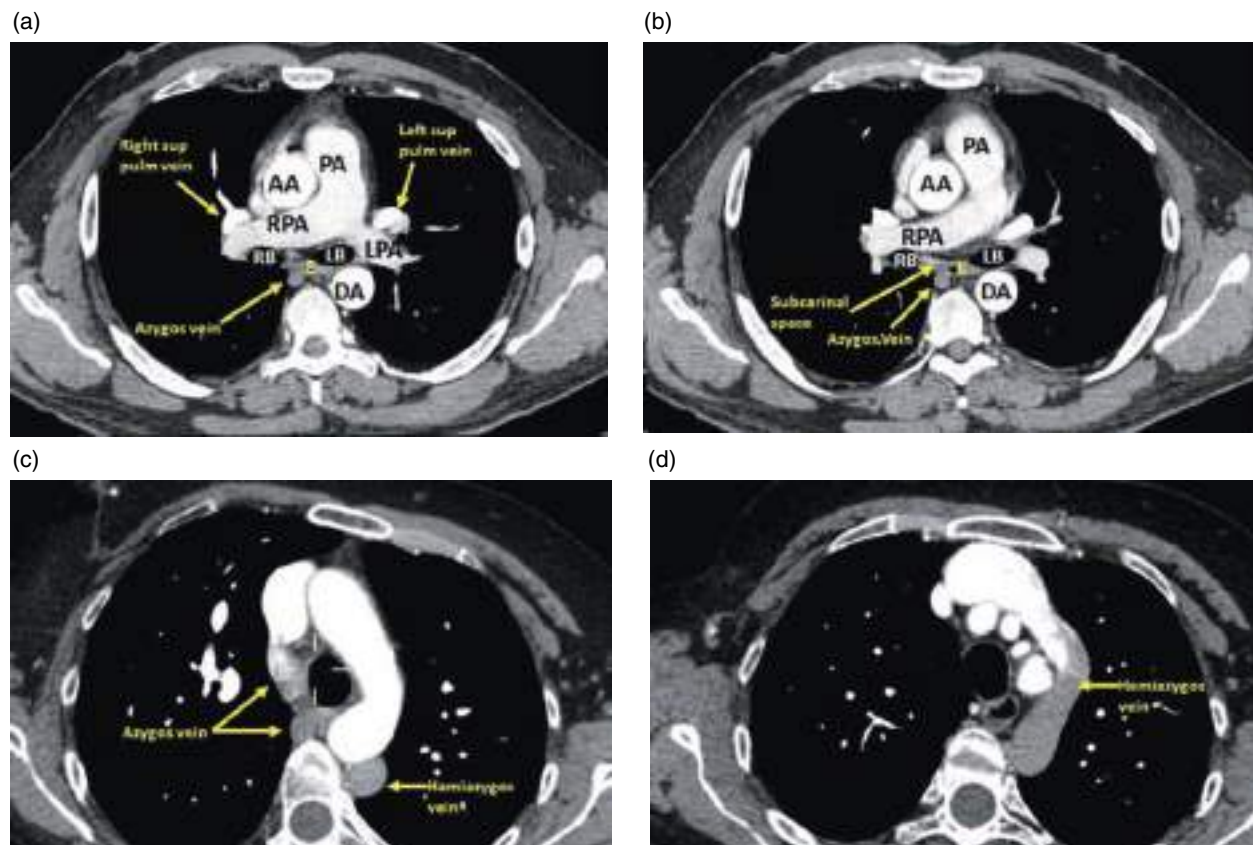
(a–d) Axial contrast-enhanced CT images (mediastinal window) at the level of the pulmonary trunk, subcarinal space, and azygo-esophageal recess. AA, ascending aorta; DA, descending aorta; PA, pulmonary artery; RP, right pulmonary artery; LP, left pulmonary artery; RB, right bronchus; LB, left bronchus; E, esophagus. Note the anatomical variant consisting of the hemiazygos vein draining directly into the left brachiocephalic vein.
